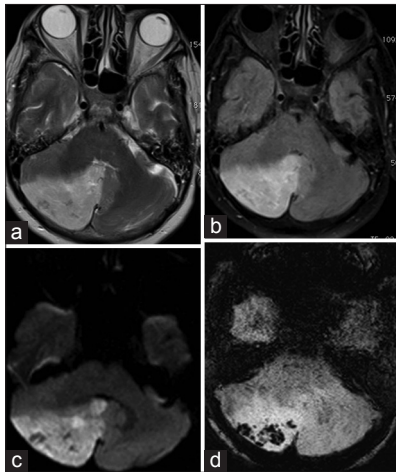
(a-d) T2 weighted and FLAIR sequence showing hyperintense lesion in the right cerebellar hemisphere with diffusion restriction. Susceptibility-weighted imaging shows hypointense blooming area in the right cerebellar hemisphere suggestive of hemorrhage
